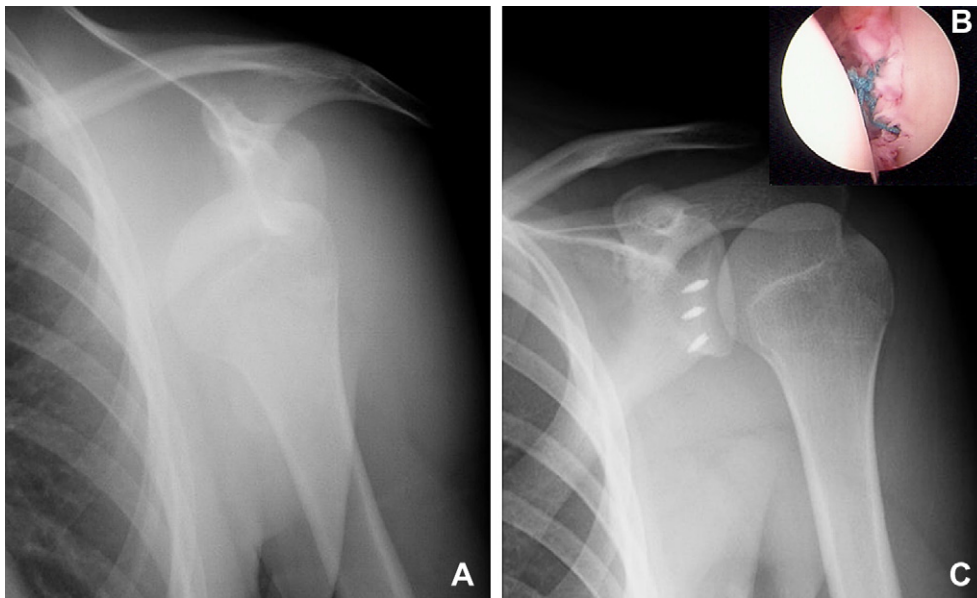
A 19-year-old soldier received arthroscopic stabilization with FASTak suture anchor fixation for traumatic first-time anterior shoulder dislocation. (A) Preoperative radiography showing left shoulder anterior dislocation. (B) Completed three suture anchors repair. (C) Postoperative radiography.
